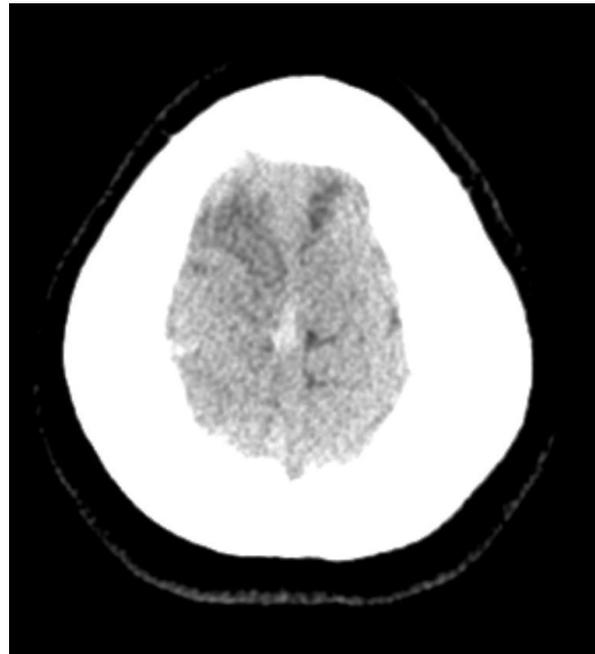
Axial CT showing Thrombosis in the superior sagittal sinus and surrounding cerebral vein.
